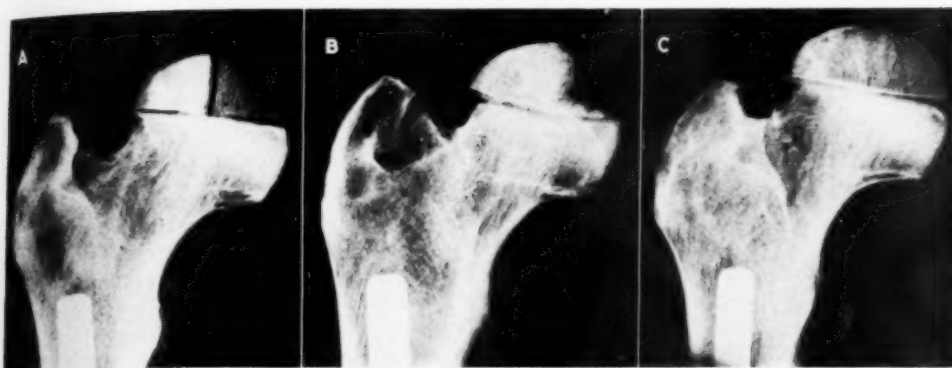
Roentgenograms of an adult femur fashioned so that the upper hemisphere of the head represents the femoral capital epiphysis. The hemisphere was sectioned in quadrants, and the anteromedial quadrant was removed. A. Plane I, anteroposterior view, shows that, although the contour of the epiphysis is apparently normal, the absence of the anteromedial quadrant is discernible by a difference in density between the medial and lateral halves. B. Plane II, internal rotation, demonstrates the defect caused by the removal of the quadrant, seen in profile. C. Plane III, external rotation, shows complete veiling of the absence of the quadrant because of the overlapping of normal bone. This clearly demonstrates that a defect as large as one-fourth of the capital epiphysis might easily be overlooked on certain projections, whereas it is clearly seen on other projections. Exact anatomical localization of the defect is obvious, since it occupies a medial position on view A (anteroposterior), and is seen on profile medially on internal rotation (view B). If (B) and (C) were reversed so that the defect were seen on profile in external rotation, the absent quadrant would be in the posteromedial position. This principle can be applied to defects in any portion of the epiphysis.
